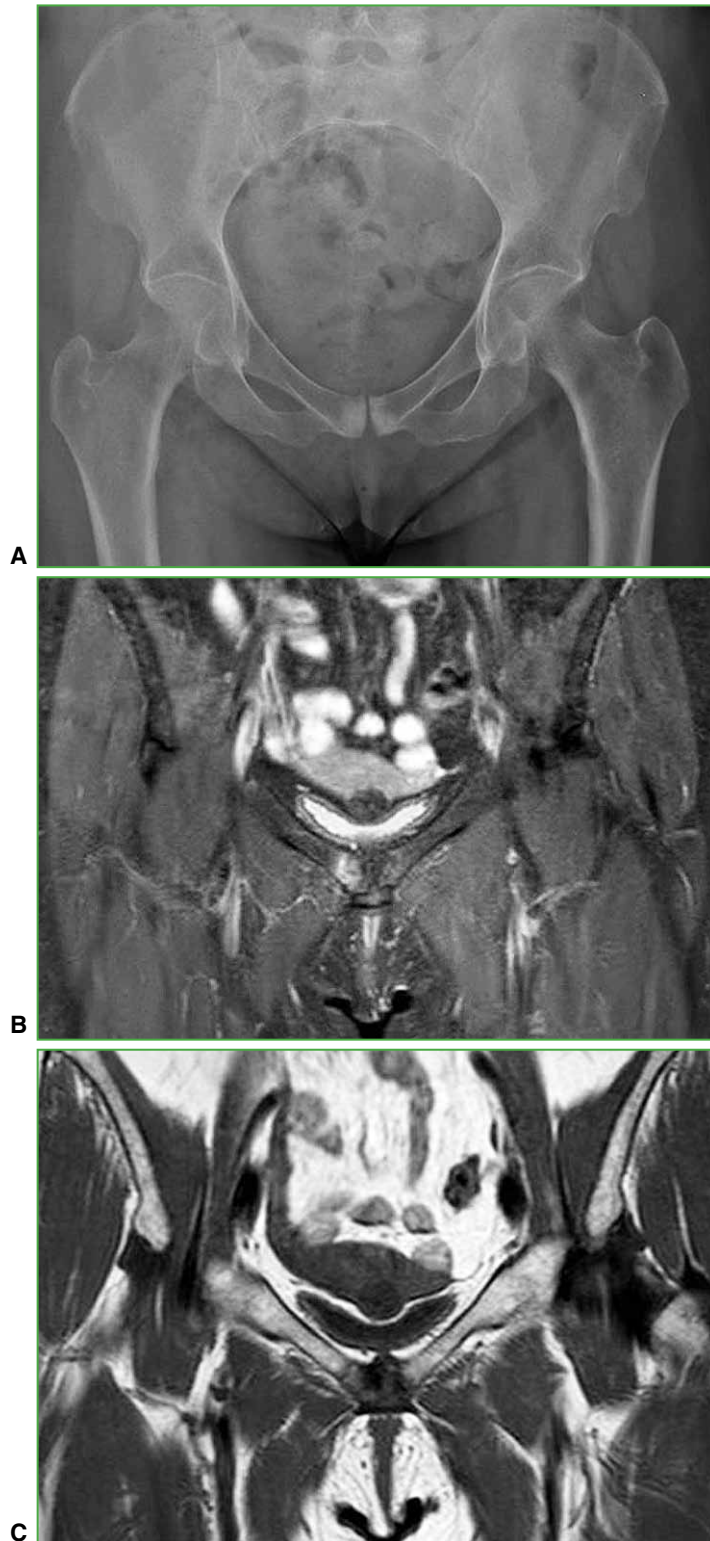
Patient at 8 months. A. Anteroposterior pelvic radiograph with identical features after conservative treatment. B. Pelvic MRI, coronal plane, STIR sequence. Bone edema can be observed in the right pubic ramus, a sign of absence of fracture consolidation. C. Pelvic MRI, T1-weighted sequence. The fracture trace in the right pubic ramus is still observed.
